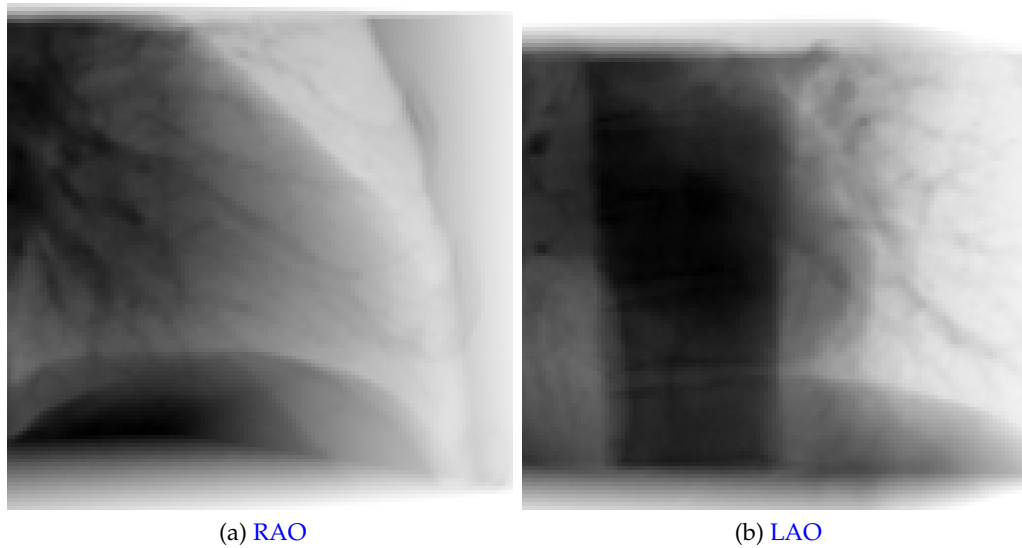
Exemplary samples of generated DRRs of a patient for the (a) RAO and the (b) LAO angulation ranges. The main difference between the DRRs is that the shadow of the aorta overlays the LV in LAO images (dark band in the center of the LAO projection). Thus, the RAO images are more similar to clinical X-rays than the images of the LAO images.
